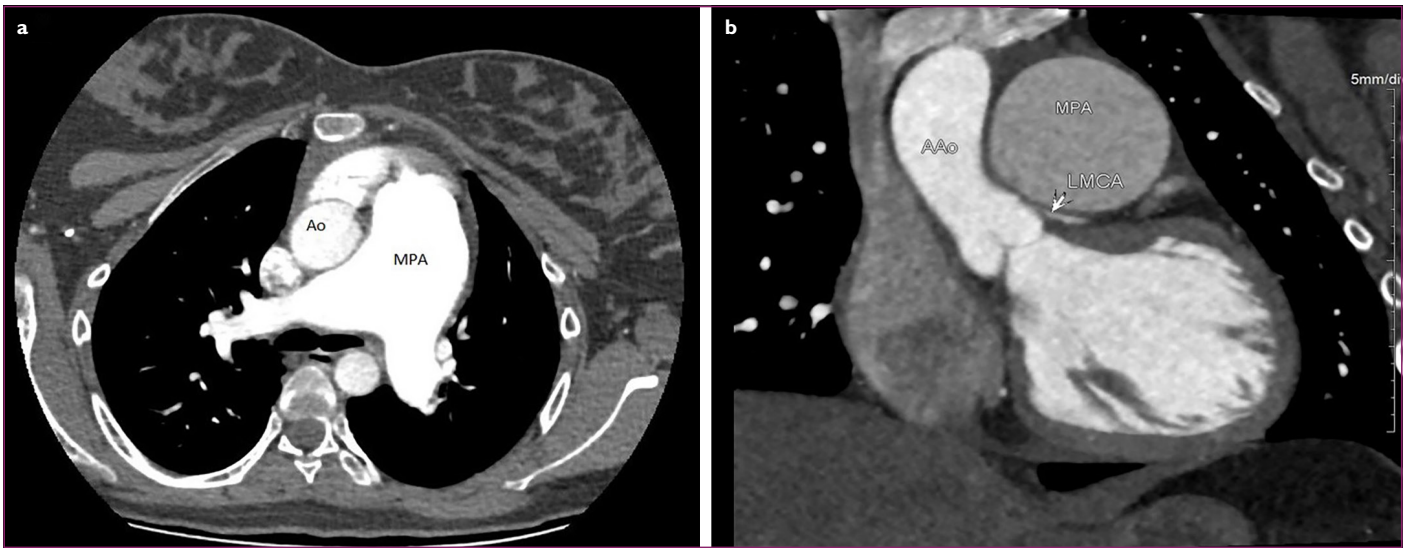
(a) An aneurysmal dilatation of the pulmonary artery was observed on thorax CT. (b) On coronary CT angiography, an external compression of the aneurysmal pulmonary artery was observed.
